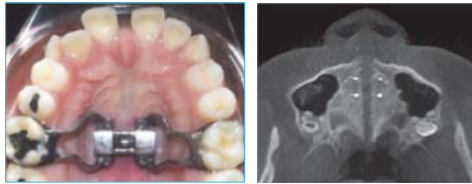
Clinical photo of MARPE appliance (left)³ and CBCT following rapid palatal expansion (right).
